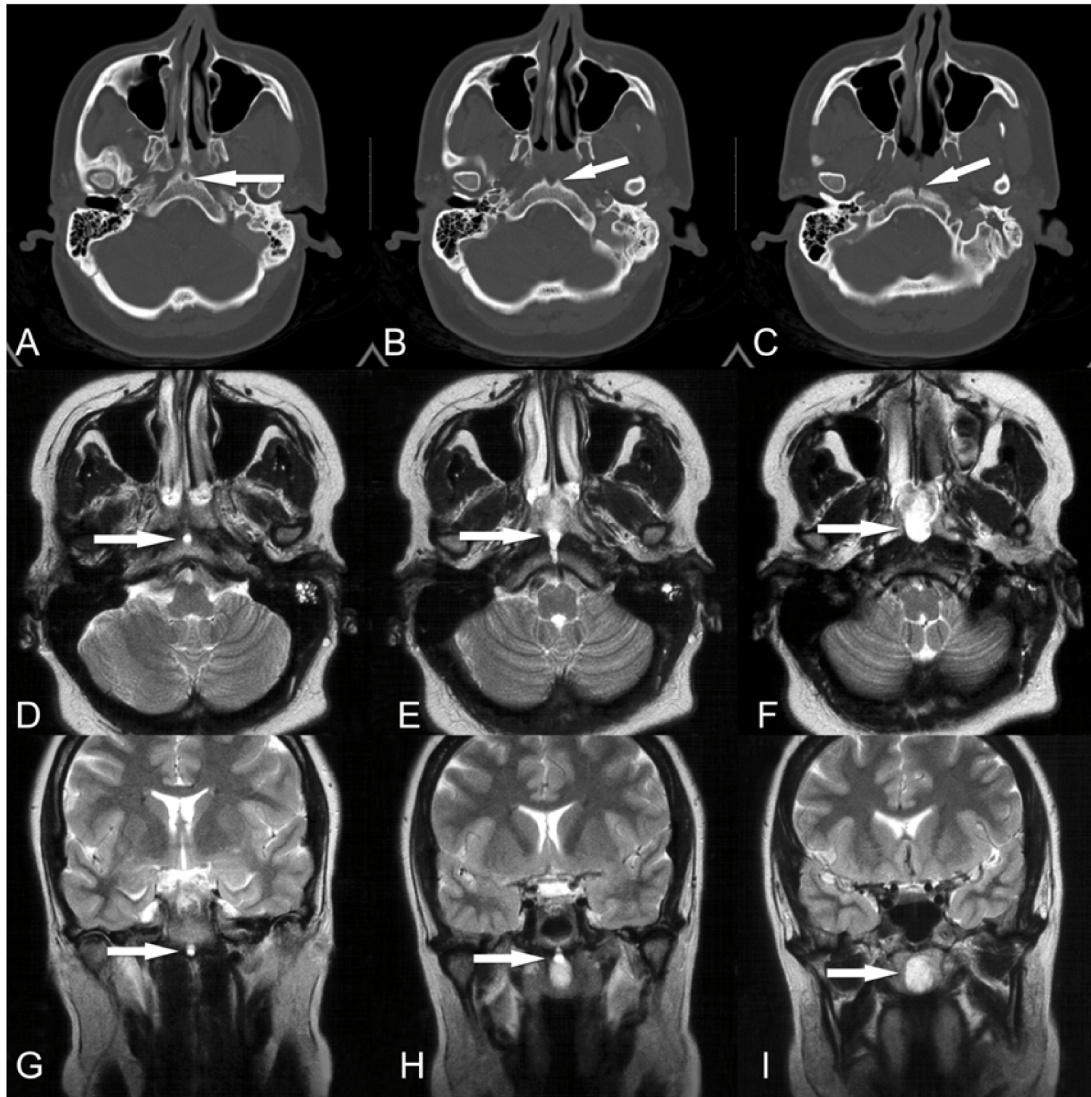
Case 1. Consecutive caudal to cranial sequences on noncontrast CT (a, b, c), axial (d, e, f), and coronal (g, h, i) T2-weighted MR imaging demonstrating the presence of a well-corticated canal within the clivus (arrows in a, b, c, d, g) in continuity with the chordoma (arrows in e, f, h, i).
